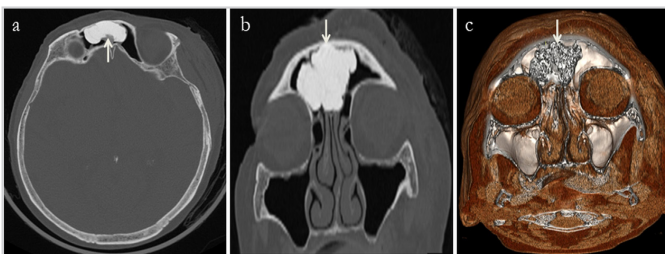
A giant osteoma (white arrows) in the right frontal sinus of an 89-year-old female patient. a) axial, b) coronal, c) volume-rendering CT images
